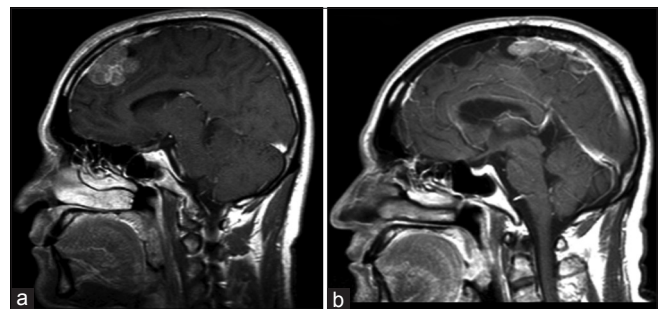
T1 sagittal post contrast MRI image revealing falx meningioma (a). 2 years after surgery T1 sagittal post contrast MRI image indicating new meningioma posterior to the operative cavity (b)
